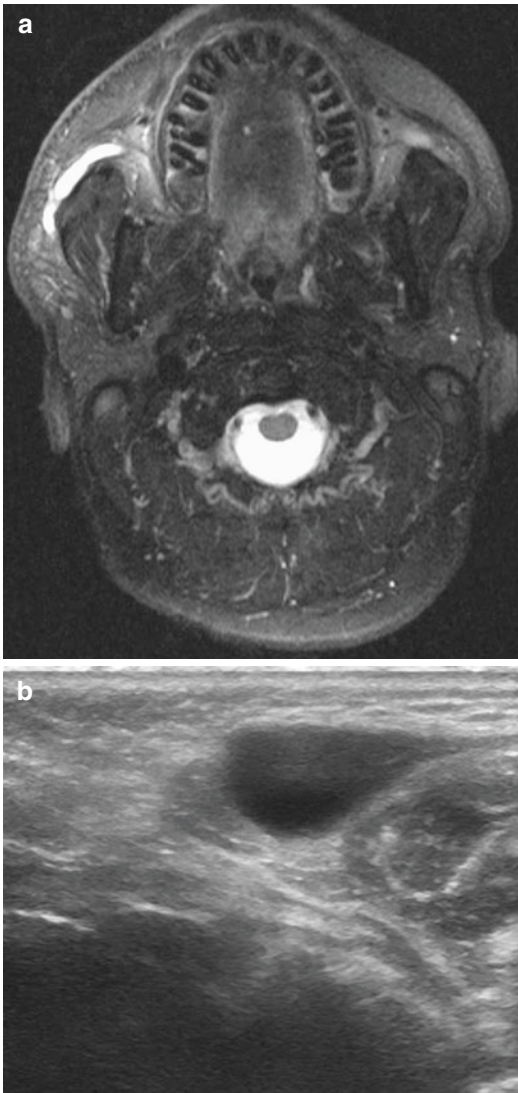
Right parotid megaduct as viewed on MRI (a) and left Stensen's megaduct as seen on ultrasound (b)
